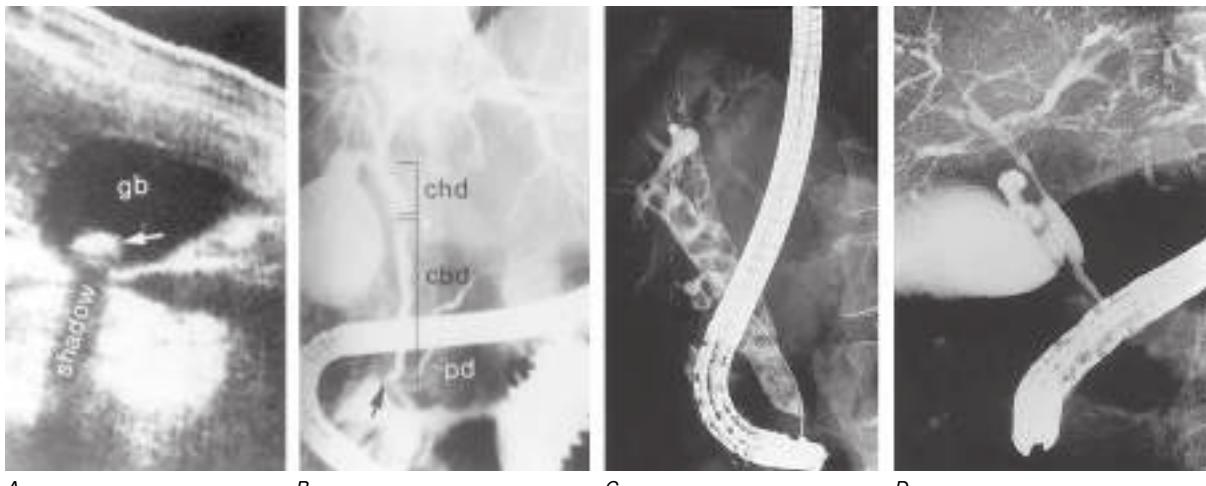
Examples of ultrasound and radiologic studies of the biliary tract. *A*. An ultrasound study showing a distended gallbladder (GB) containing a single large stone (arrow), which casts an acoustic shadow. *B*. Endoscopic retrograde cholangiopancreatogram (ERCP) showing normal biliary tract anatomy. In addition to the endoscope and large vertical gallbladder filled with contrast dye, the common hepatic duct (CHD), common bile duct (CBD), and pancreatic duct (PD) are shown. The arrow points to the ampulla of Vater. *C*. Endoscopic retrograde cholangiogram (ERC) showing choledocholithiasis. The biliary tract is dilated and contains multiple radiolucent calculi. *D*. ERCP showing sclerosing cholangitis. The CBD shows areas that are strictured and narrowed.
